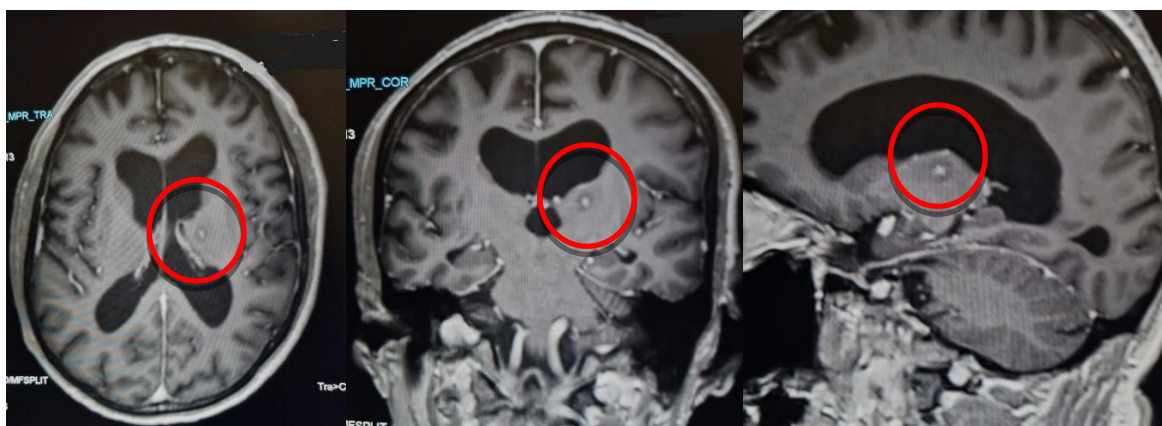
Axial, coronal and sagittal views of enhanced MRI images showing a nodular contrast-enhancing lesion in the left thalamus creating a "target" sign, characteristic of a mycotic aneurysm.
